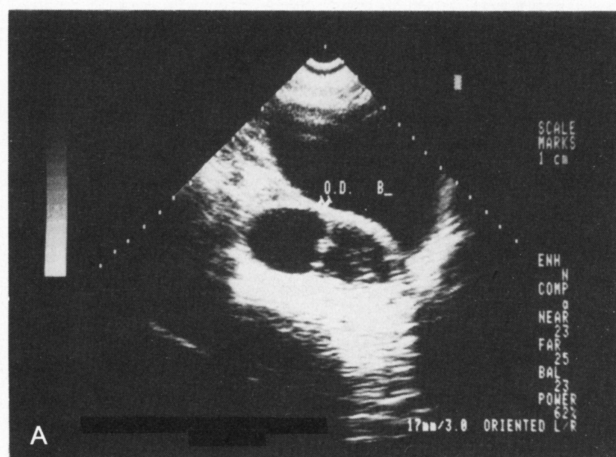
Thirty-one-year-old patient with endometriosis and chocolate cyst on the right ovary (OD) diagnosed by laparoscopy. Real-time ultrasound image of large (72.7 cm³) cyst before (A) and after 6 months of gestrinone therapy by vaginal route, 5.0 mg twice weekly (B). Note the disappearance of the cyst. Ovarian diameter after treatment was 13.2 cm³.
